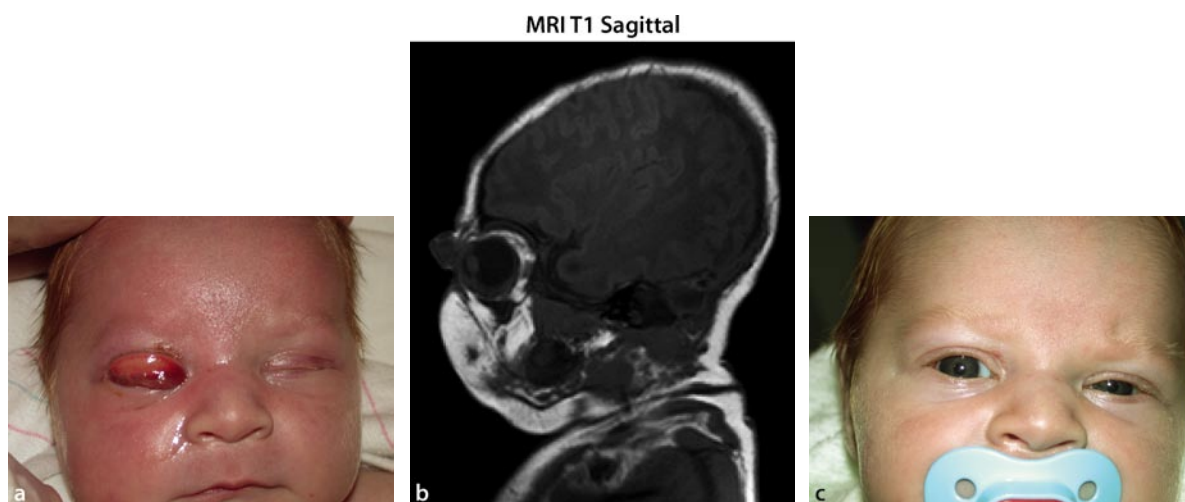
a Congenital eversion of the upper eyelid associated with edema, erythema, and prolapsed supratarsal conjunctiva. The eyelid eversion persisted despite treatment with topical antibiotic/steroid and taping of the eyelid. b An MRI sagittal
